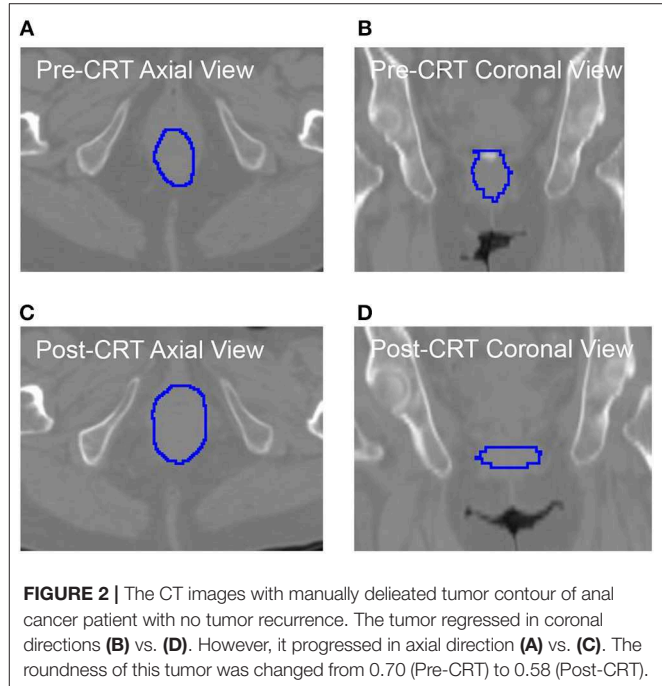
The CT images with manually delineated tumor contour of an anal cancer patient with no tumor recurrence. The tumor regressed in coronal directions (B) vs. (D). However, it progressed in axial direction (A) vs. (C). The roundness of this tumor was changed from 0.70 (Pre-CRT) to 0.58 (Post-CRT).
